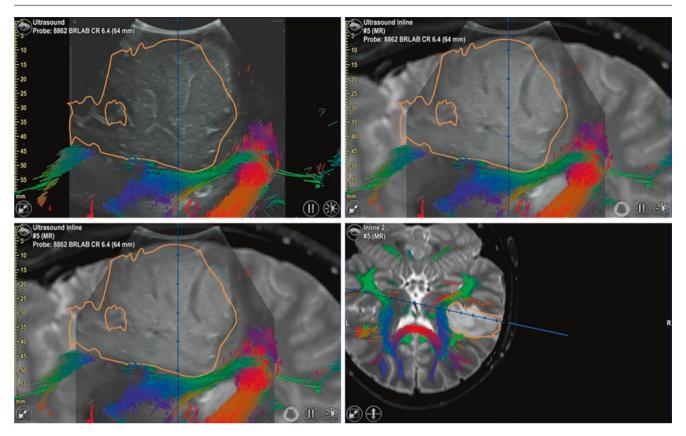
Screenshot of intraoperative ultrasonography overlaid onto a preoperative navigation planning scan. The image demonstrates a subtle but definite brain shift even though the dura has yet to be opened
